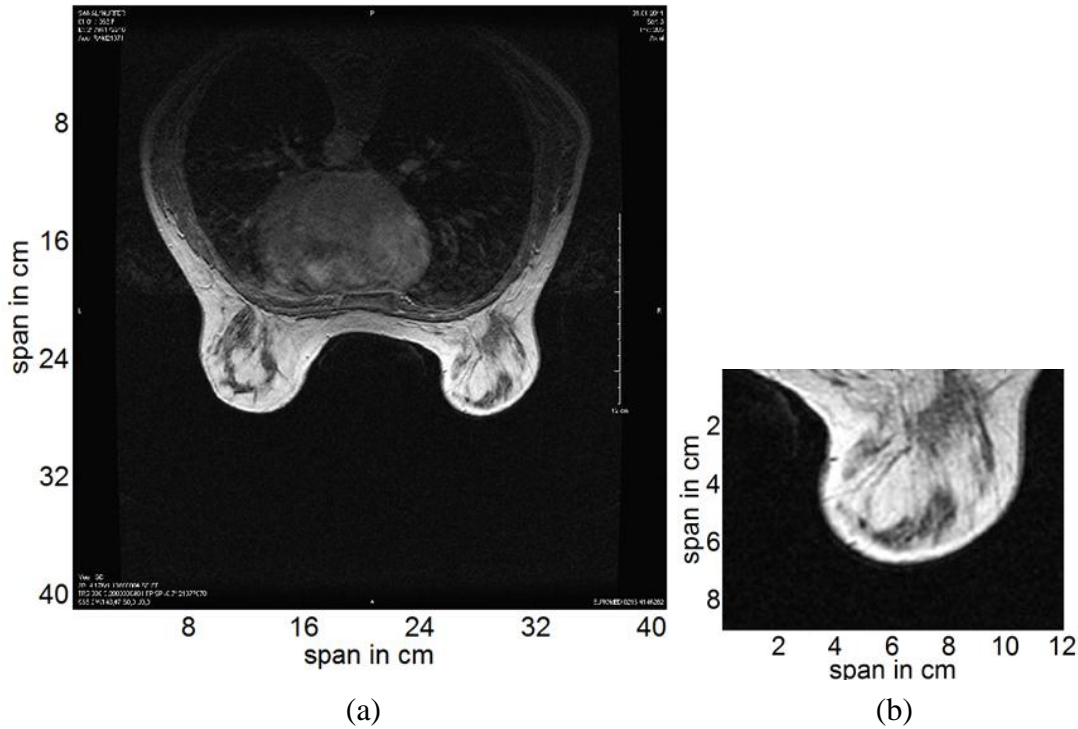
Extraction of the breast tissue from axial slices of 3-D MRI data.
